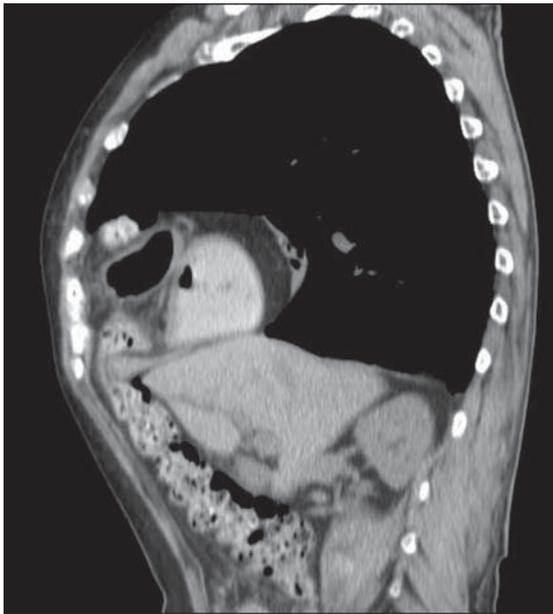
HRCT – sagittal reconstruction - showing the diaphragmatic defect
